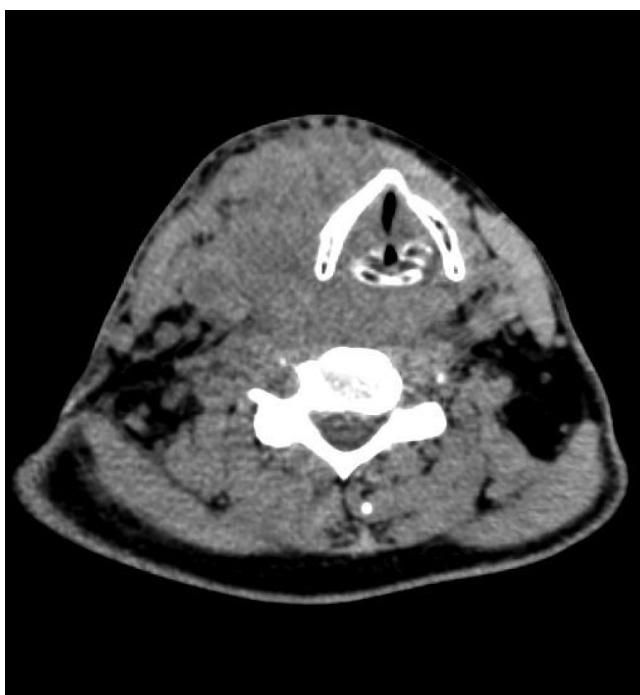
The CT-scan of the neck (Patient1) presenting large thyroid mass, compressing and moving trachea to the left. No visible blood flow in the veins of the neck. Signs of collateral circulation.
